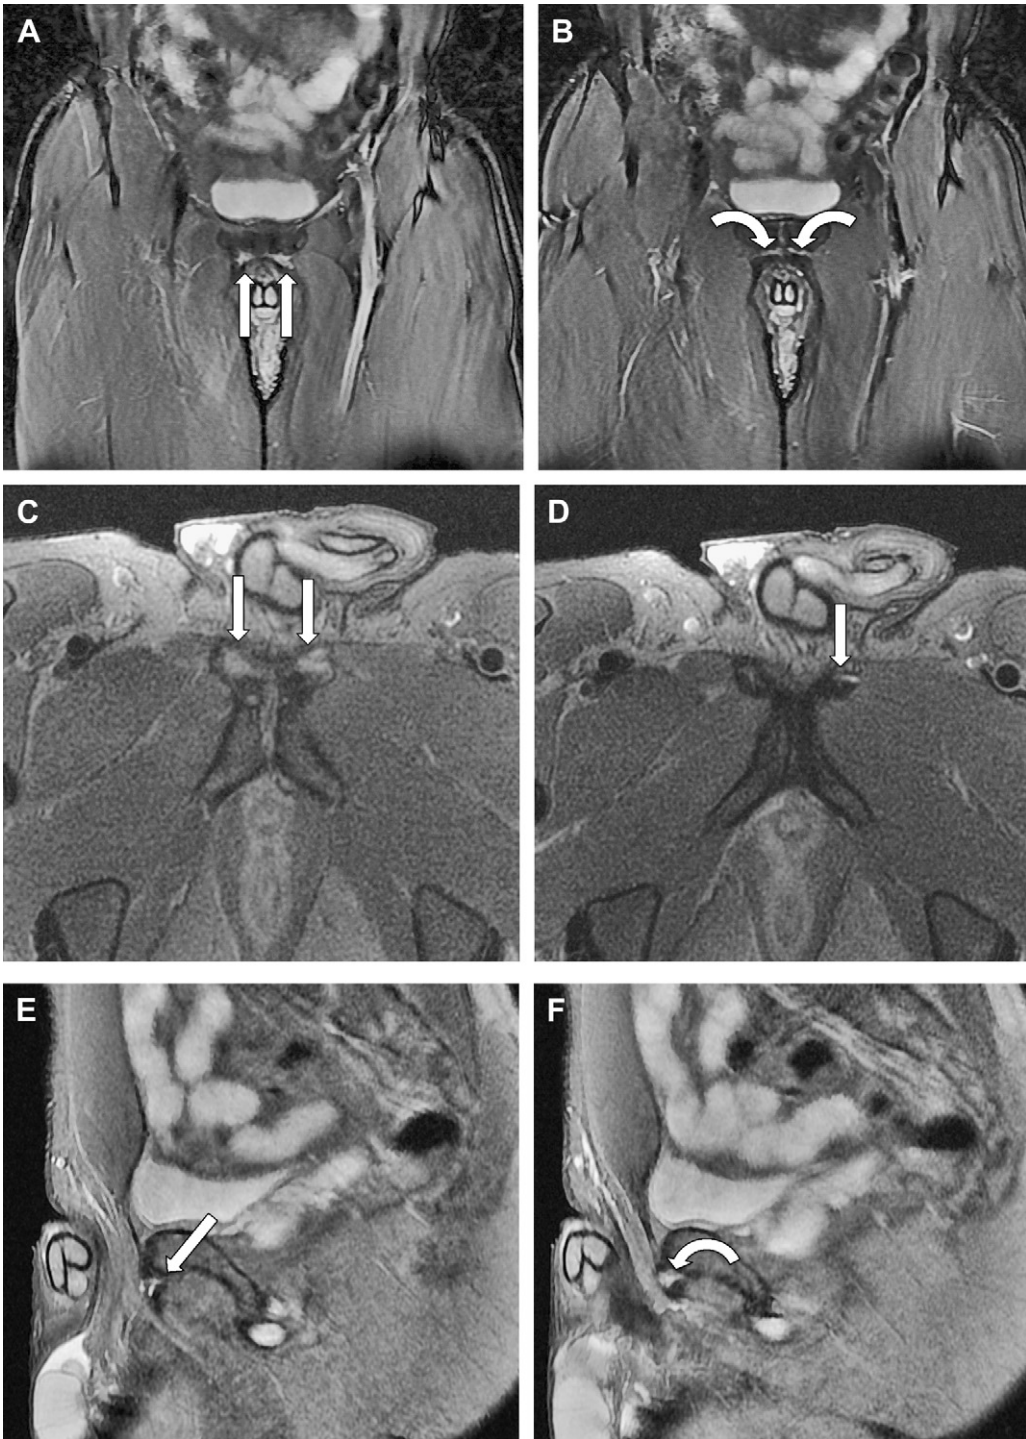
(A) Coronal fat-saturated T2-weighted MR image. Bilateral severe adductor longus origin tendinosis (arrows). (B) Coronal fat-saturated T2-weighted MR image. Bilateral secondary clefts extending from the pubic symphysis into the adductor attachments, indicating some disruption of the prepubic aponeurotic complex tissue (curved arrows). (C) Axial fat-saturated T2-weighted MR image demonstrating bilateral adductor longus tendinosis (arrows). (D) 3D Axial fat-saturated T2-weighted MR image demonstrating a small tear of the left adductor longus tendon (arrow). (E) Sagittal fat-saturated T2-weighted MR image. Small tears of the origin of the left adductor longus tendon (arrow). (F) Sagittal fat-saturated T2-weighted MR image. This image demonstrates more severe adductor longus tendinosis that involves the prepubic aponeurotic complex (curved arrow).
